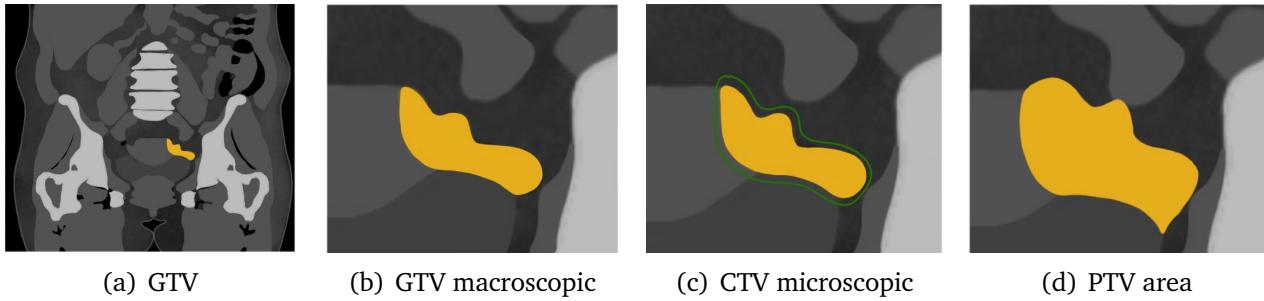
Coronal view the same image slice of a CT image, with different window cropping (Patient id: 49, slice 251). White (radiopaque) areas represent high-density tissues, and black (radiolucent) areas represent low-density tissues within the window range.
